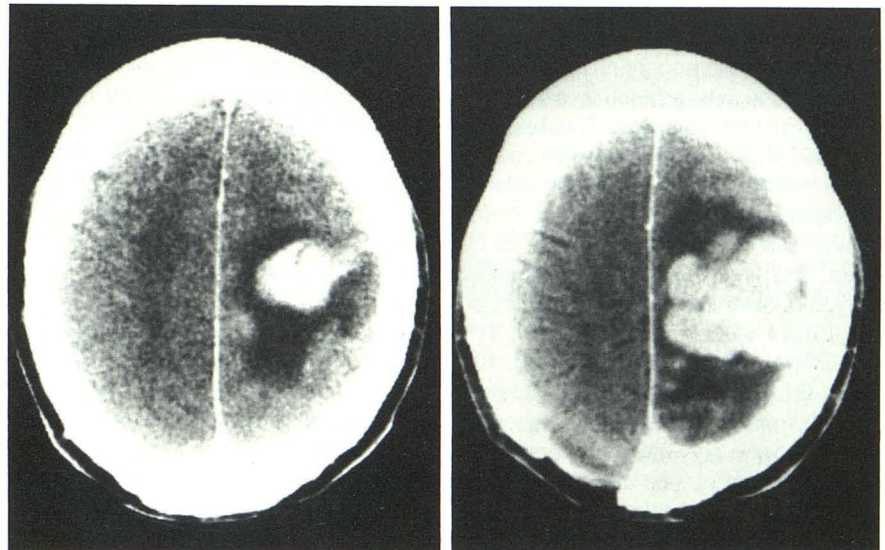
Contrast-enhanced CT scans. Intensely and homogeneously enhancing peripheral lesions.
